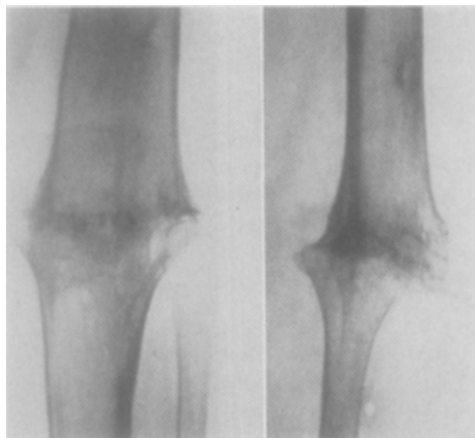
Case 15: roentgenograms of left knee; ankylosis after arthrodesis.
